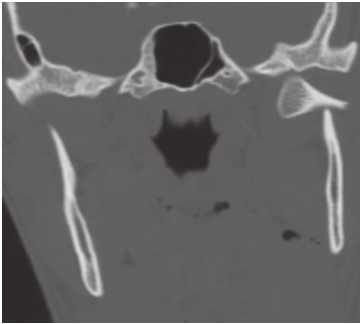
Subcondylar mandible fracture seen on coronal CT. The subcondylar region of the mandible is well visualized on coronal cuts. Notice that the proximal fragment is displaced medially by the lateral pterygoid muscle.
